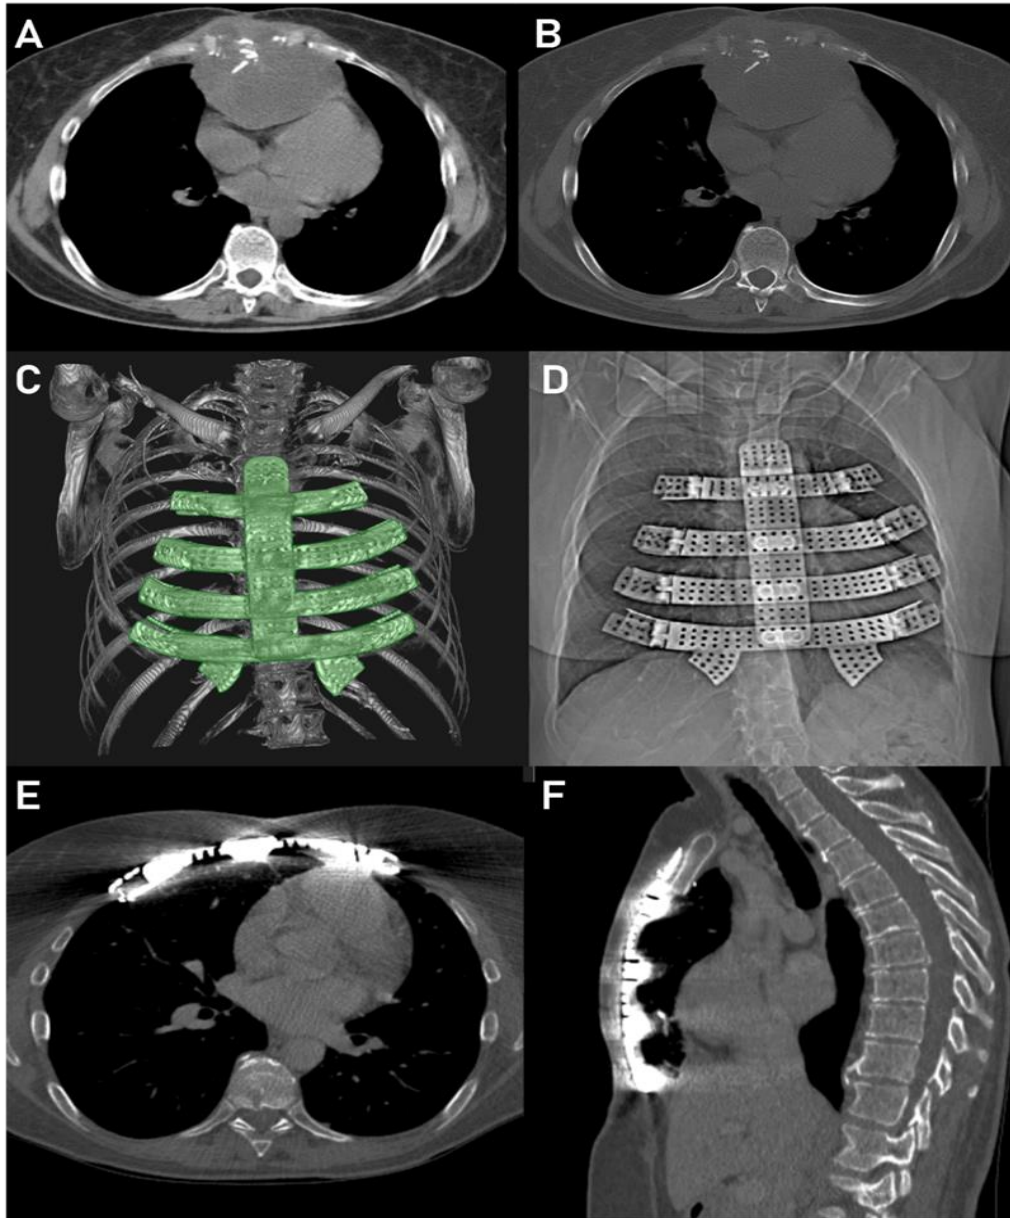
Thorax CT: (A) axial view soft tissue window, and (B) bone window, shows the massive tumor located in the *Manubrium sternum* with retrosternal expansion; (C) three-dimensional view, and (D) CT topogram, (E) axial view, and (F) sagittal view shows the tissue-engineered titanium sternum six months after surgery; All images are published in accordance with the patient's consent
